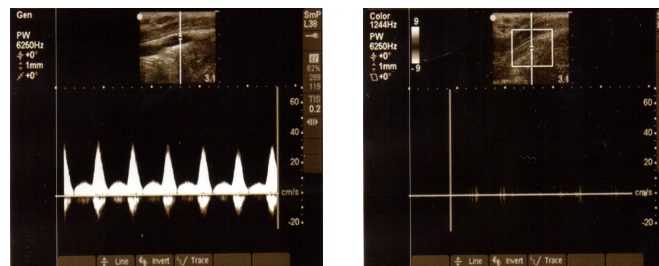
Spectral Doppler of femoral artery demonstrating cessation of flow
